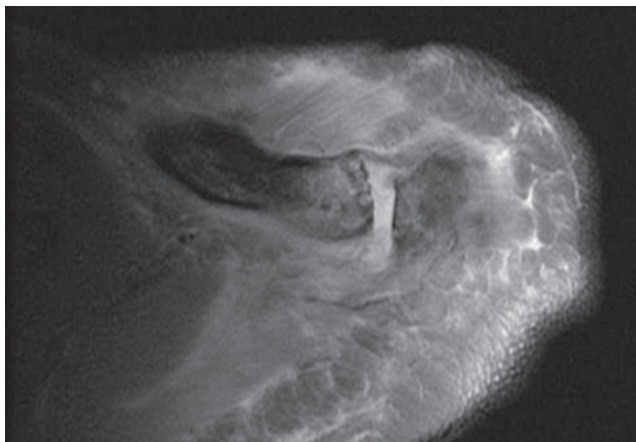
Axial magnetic resonance imaging shows increased signal uptake in acromioclavicular joint and surrounding soft tissue with bony edema of distal clavicle and acromion.
